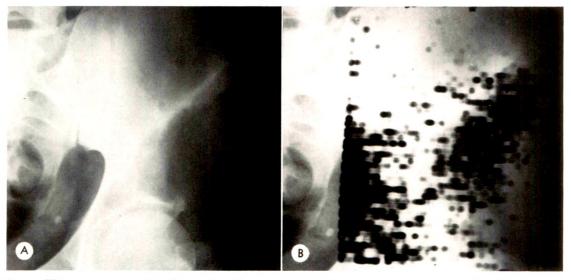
Thirty-seven year old white male with a poorly differentiated malignancy, probably reticulum cell sarcoma, and multiple destructive lesions of bone (N.C.B.H. #03 15 22). (A) Anteroposterior roentgenogram of the left ilium demonstrating one of the large lytic lesions. (B) Roentgenogram and scan superimposed demonstrating the tumor by Tc99m. Note the normal bladder uptake medial to the ilium.
